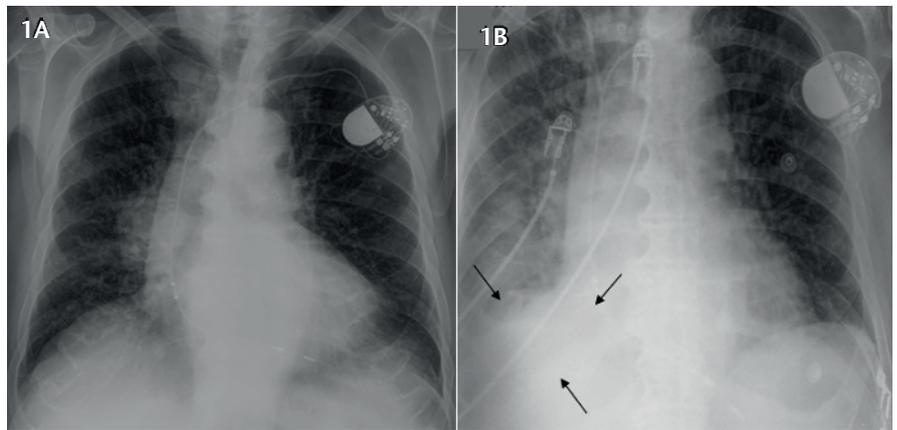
(A) Chest radiograph on admission reveals mild interstitial lung edema and no signs of pneumonia. (B) Chest radiograph on the fourth day shows focal parenchymal abnormality related to consolidation of the right lower lobe suggesting pneumonia (black arrows).
